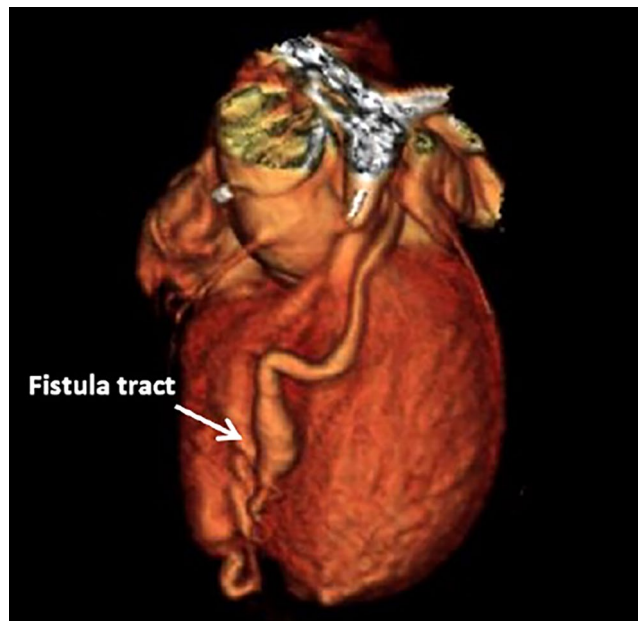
Three-dimensional volume-rendered image of the coronary fistula on computed tomography angiography.
